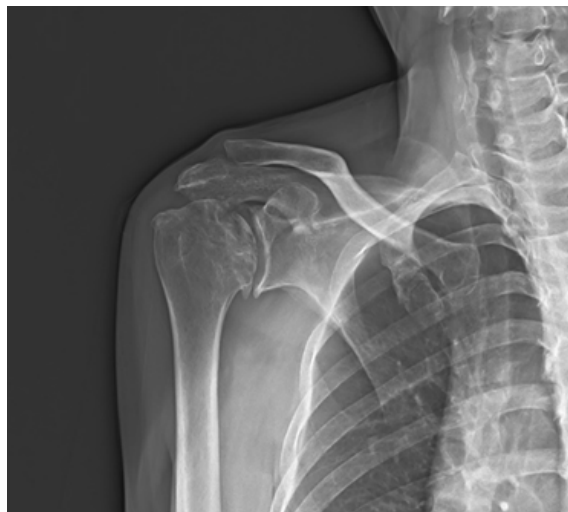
Anteroposterior radiograph of the shoulder shows articular collapse on the superomedial side of the humeral head at 3-year post-operation.
